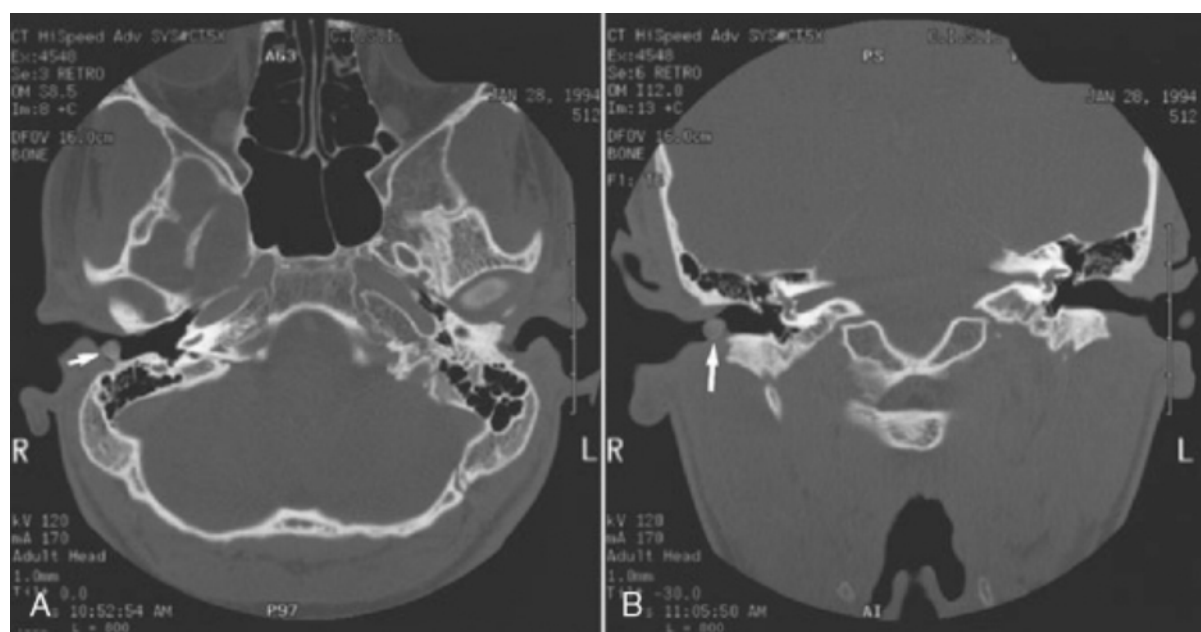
Axial (A) and coronal (B) bone-windowed computed tomography images demonstrating a pedunculated attachment to the lateral posterior canal wall (arrows). The remaining external auditory canal and middle and inner ear are normal.
